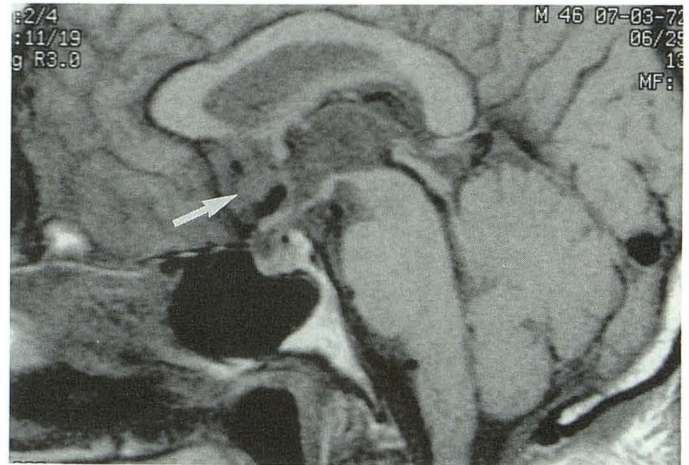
T1-weighted sagittal MR image showing the position of the normal septal area consisting of the subcallosal area (*thin arrow*) and smaller paraterminal gyrus (*thick arrow*) under the corpus callosum and anterior to the third ventricle.
